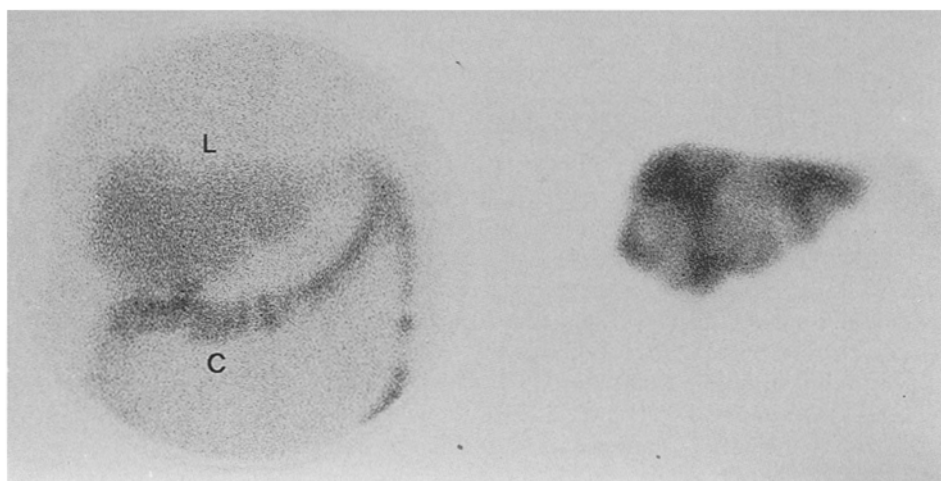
Anterior image of the abdomen, 24 h after injection of [^{123}I -Tyr 3]-octreotide (*left panel*) and $^{99\text{m}}\text{Tc}$ -colloid scintigraphy of the liver (*right panel*) in patient 13. *L*, Liver; *C*, colon. Note that the cold spots on the *right panel* take up labelled octreotide (*left panel*)
